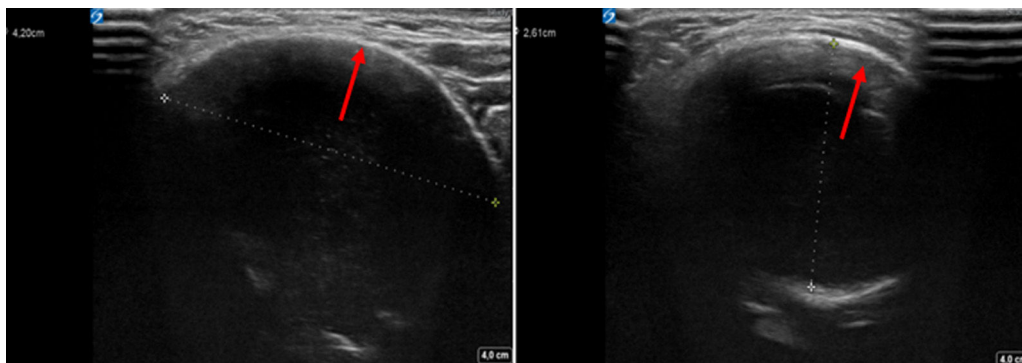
Ultrasound scan showing a hypoechoic cystic lesion measuring 4 cm at minimum and expanded and seemingly intact cortical bone (red arrow).
